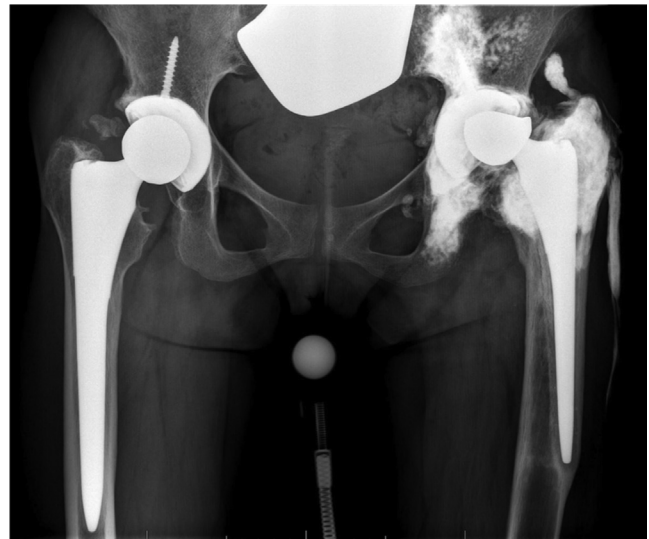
Preoperative anteroposterior radiograph of the hips from June 2017 demonstrating a diffuse sclerotic reaction extending into the soft tissue along the proximal aspect of the thigh, an aspherical femoral head likely due to chronic superior erosion, a loose femoral component in valgus, and a loose acetabular cup.
